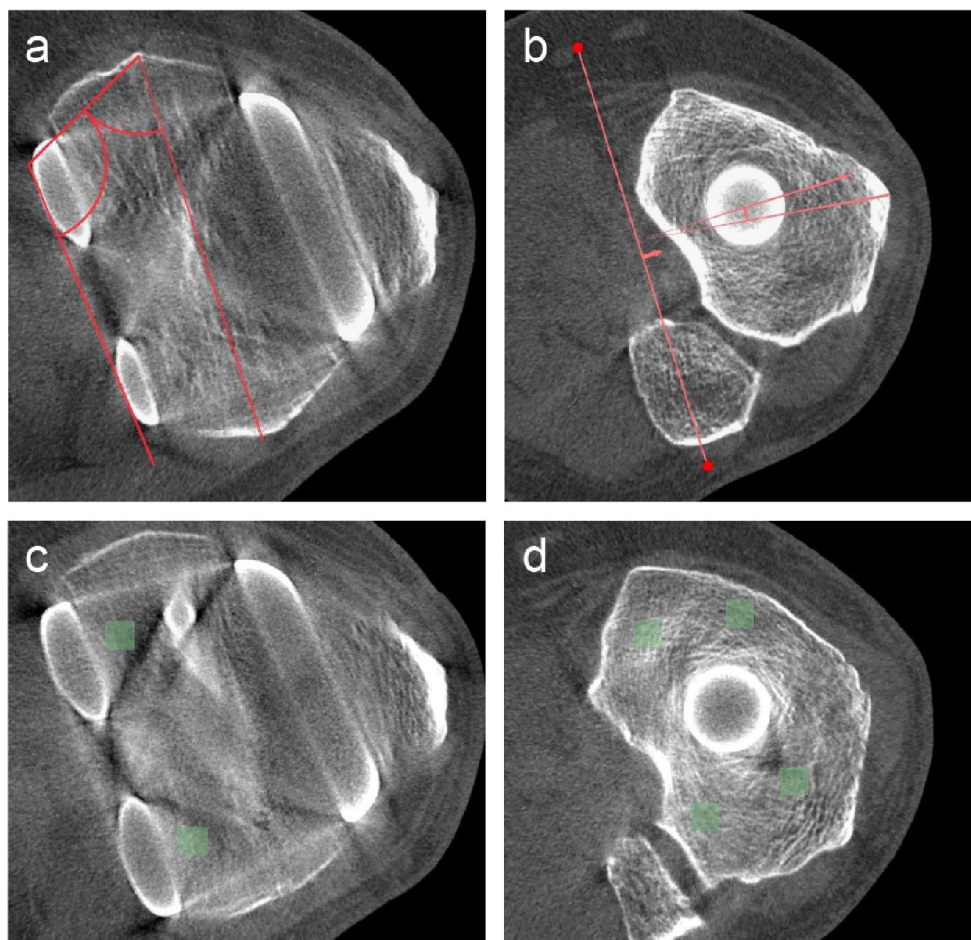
Axial view of the knee joint using weight-bearing computed tomography with measurements for femoral and tibial component rotation and bone density. (a) Femoral component rotation. Measured by calculating two angles using the trans-epicondylar axis and a line through the posterior edge of the femoral condyles, and then subtracting their sum from 180° to determine the final rotation angle. (b) Tibial component rotation. Measured using the angle formed between two reference lines: the first passing through the center of the tibial keel, perpendicular to the posterior tibial plate, and the second extending from the point of intersection to the tip of the tibial tuberosity. (c) Femoral bone density measurement. Green boxes highlight examples of the regions of interest (ROIs) in the femur, specifically at the posterior part of the lateral and medial condyles. Bone density was assessed using greyscale values in $6\text{ mm} \times 6\text{ mm} \times 6\text{ mm}$ ROIs. (d) Tibial bone density measurement. Green boxes highlight examples of the ROIs in the tibia, specifically under the four pegs (anterolateral, posterolateral, posteromedial, and anteromedial). Bone density was assessed using greyscale values in $6\text{ mm} \times 6\text{ mm} \times 6\text{ mm}$ ROIs
